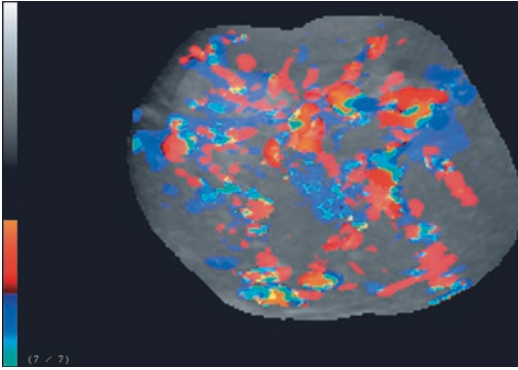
Overall tissue vascularization of the enlarged ovary as assessed by 3D power Doppler
